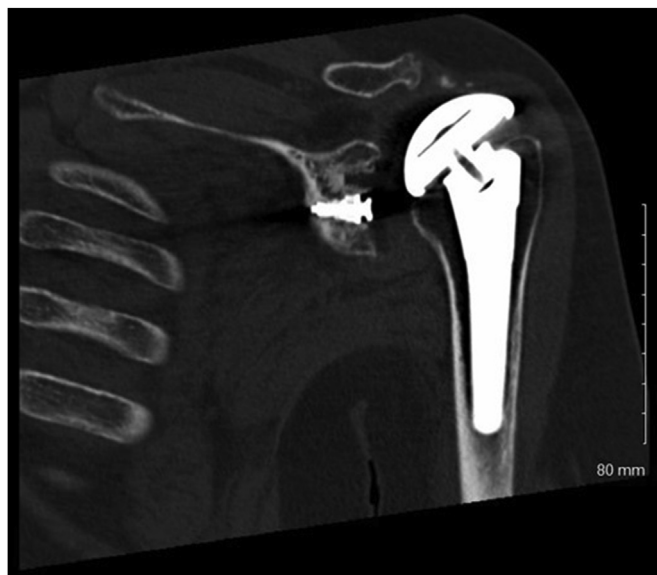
Left shoulder coronal CT of an anatomic TSA failed secondary to rotator cuff dysfunction. CT, computed tomography; TSA, total shoulder arthroplasty.
